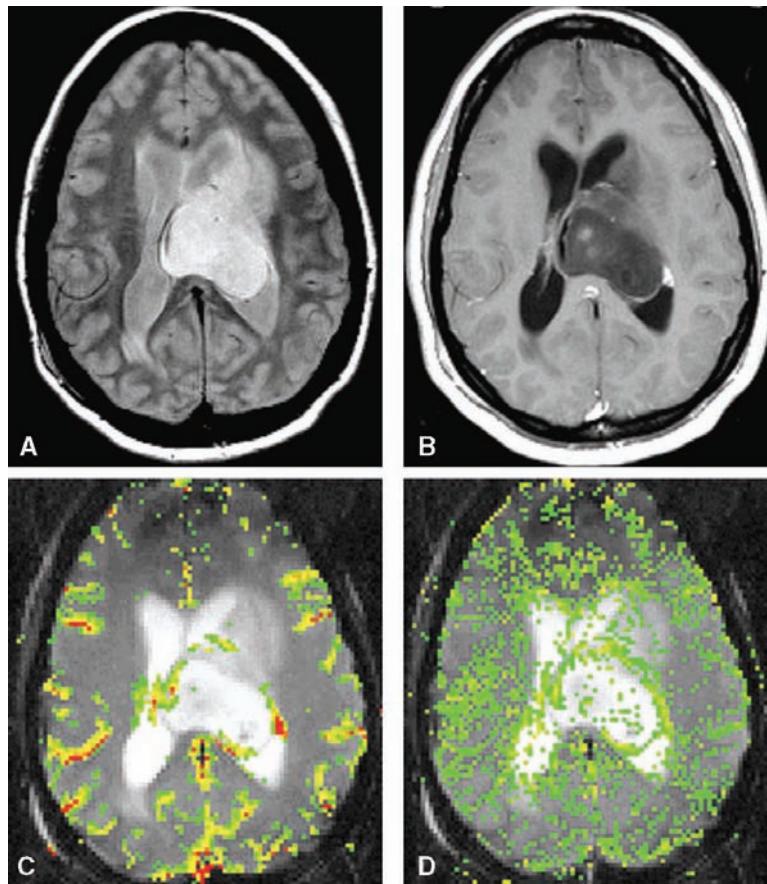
A 45-year-old woman with an anaplastic astrocytoma (WHO Grade III). (A) Proton density image demonstrates heterogeneous left-sided paraventricular lesion, extending into the left lateral ventricle. There is a small amount of vasogenic edema anterolaterally. (B) T1-weighted postgadolinium image demonstrates a small focus of peripheral enhancement. (C) Gradient-echo axial DSC MRI with relative rCBV map demonstrates elevated perfusion, on this occasion corresponding to the enhancing focus seen in Figure 3 (B). (D) SD25 color overlay map suggests intermediate vascular permeability within the solid portions of this tumor. Abbreviations: rCBV, relative cerebral blood volume; DSC MRI, dynamic susceptibility contrast MRI. Source: From Ref. 28.
